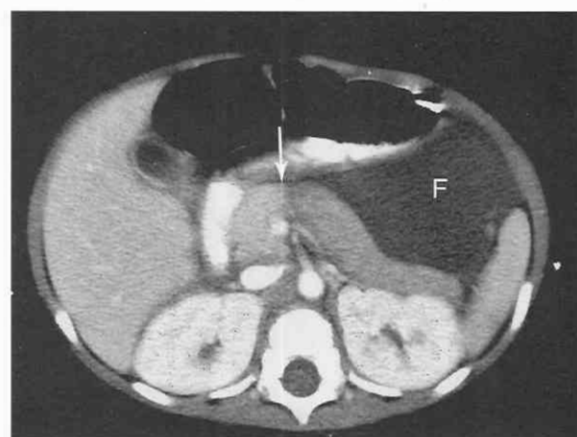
Axial CT scan shows transection (arrow) of the pancreas in the area of the neck. Note the difference in density of the body and tail compared with the head, indicating decreased vascular enhancement and edema. Also, there is a large amount of free fluid (F).
